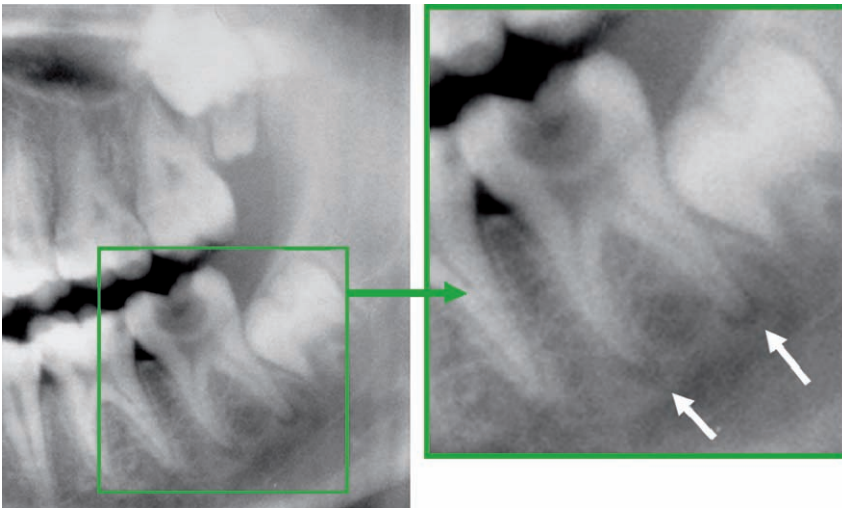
Details of a panoramic radiograph demonstrating development of periapical radiolucencies (*arrows*) at the root apices of a mandibular permanent molar tooth having extensive occlusal dental caries involving the pulp
